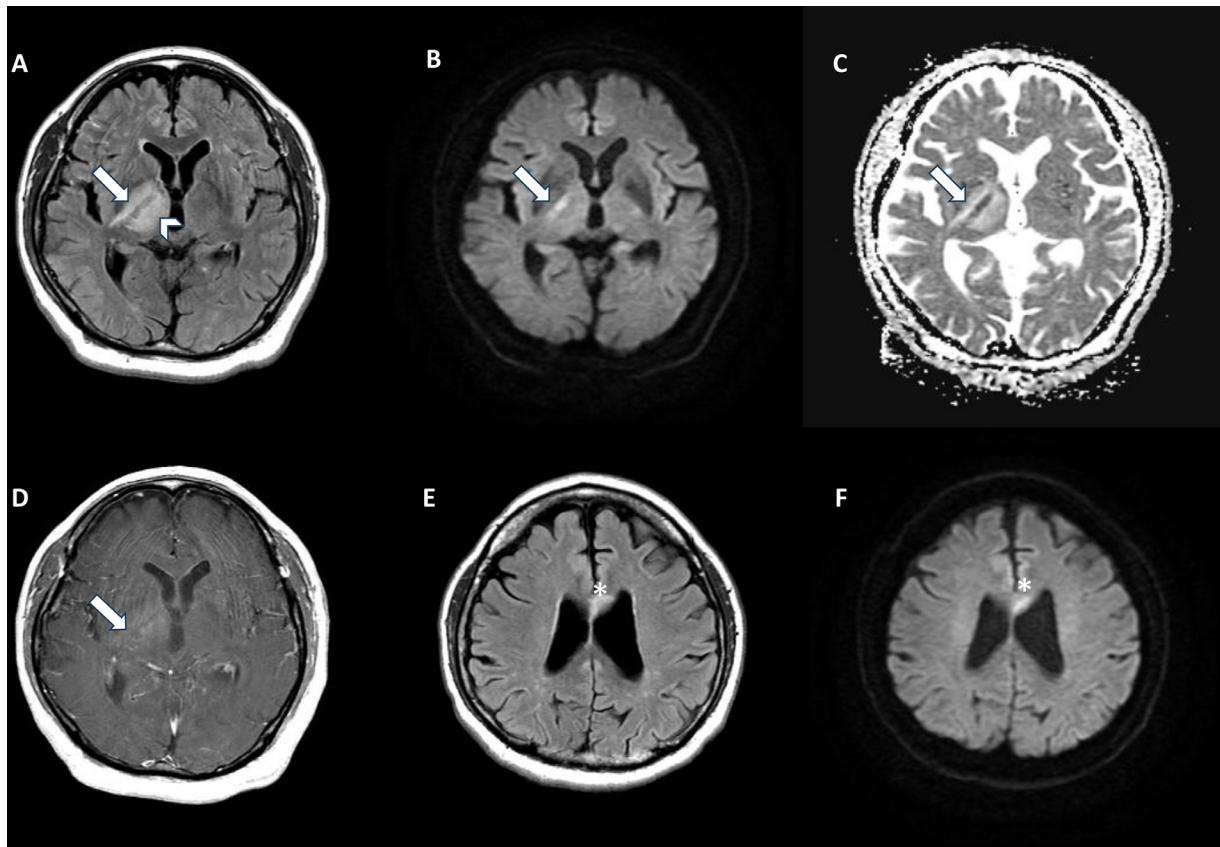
High signal intensity lesion in the right pyramidal tract (arrows) on fluid-attenuated inversion recovery (FLAIR) (A) Diffusion-weighted image (DWI) (B) and apparent diffusion coefficient (C) showing diffusion restriction in the lesion (arrows). Patchy contrast effect observed around the pyramidal tract (arrows) on post-contrast T1-WI (D). FLAIR image in the same level showing high signal intensity in the right thalamus (arrowhead), with no obvious contrast effect on post-contrast T1 images or diffusion limitation on DWI. Hyper signal was observed in the left genu of corpus callosum (*) on DWI (E) and FLAIR (F).
